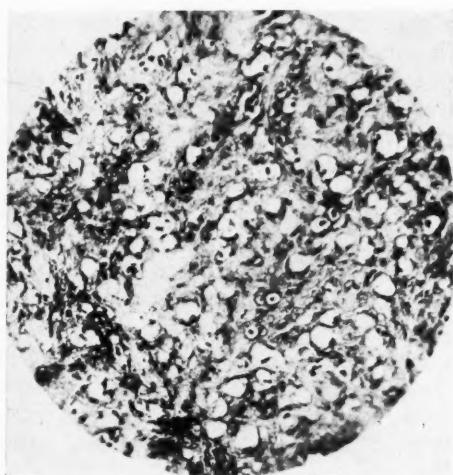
Case 6. Photomicrogram of tumor removed at operation. No preceding x-ray therapy (220 X). For description see text.
